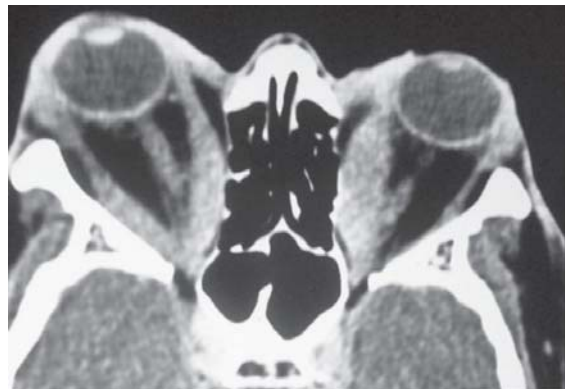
CT scan of orbit showing marked enlargement of extraocular muscles (Courtesy: Dr MS Bajaj, Dr RP Centre, New Delhi)
